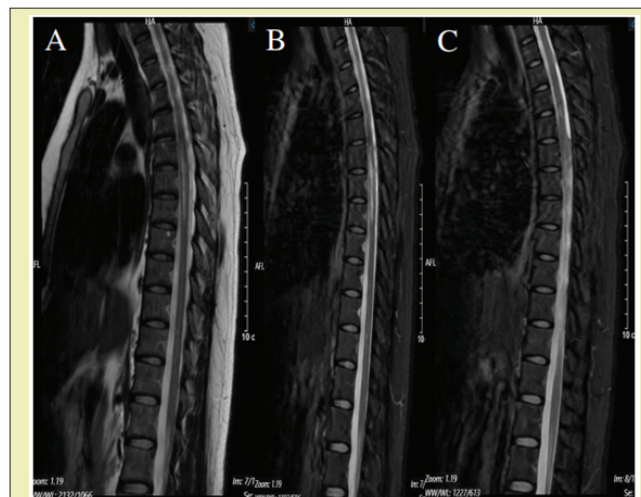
Sagittal T2 and Short tau inversion recovery (STIR) MRI imaging showing T2-3 central cord hyper intensity and T4-T6 longitudinally extensive central cord hyper intensity in keeping with longitudinally extensive transverse myelitis (LETM) as can be seen in NMOSD.
